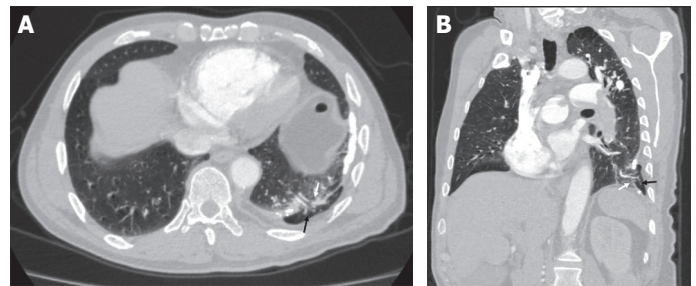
(A) Axial computed tomography (CT) and (B) oblique reformatted CT show herniated lung (black arrow), pleural defect (white arrow), pleural thickening, and calcification.
